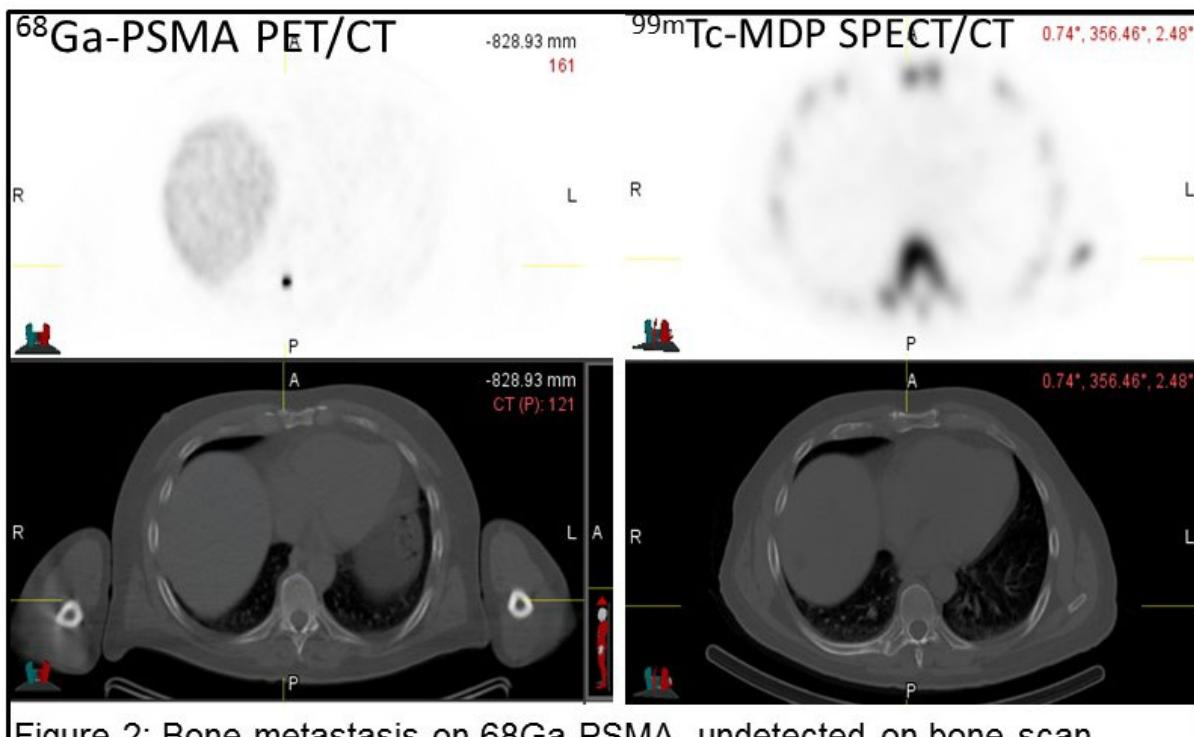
Bone metastasis on 68Ga-PSMA, undetected on bone scan.
